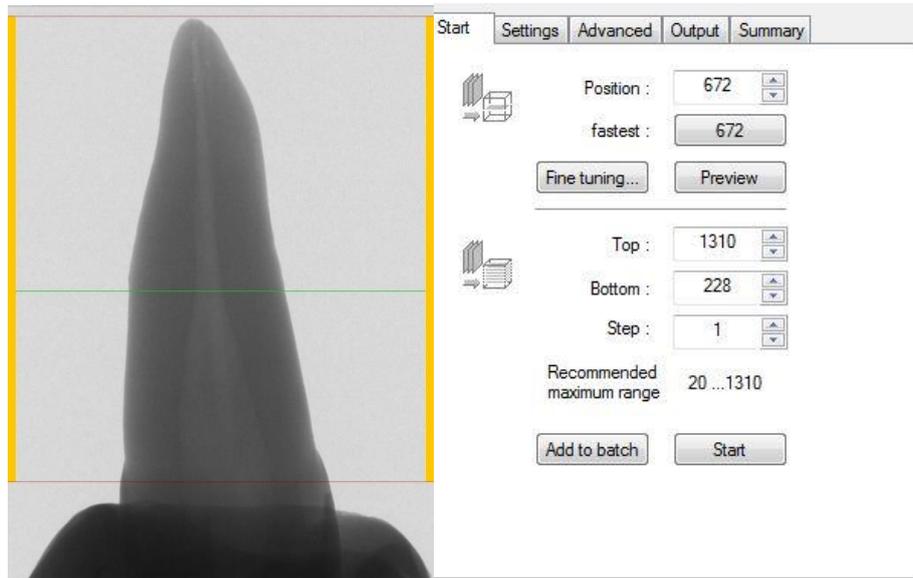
NRecon reconstruction of the entire tooth, bottom line placed near the CEJ while top line should be placed at the end of radiographic apex.
